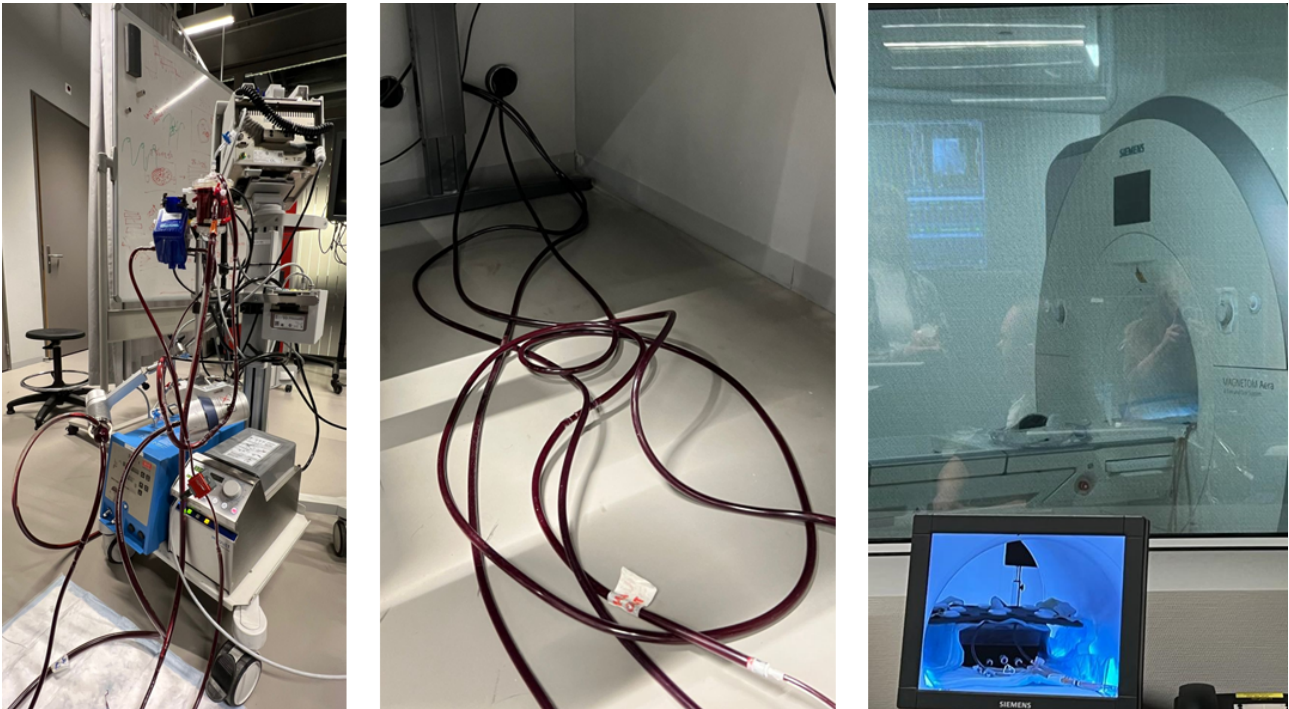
Setup for MRI experiments. The driving system is placed in the control room of the MRI. The 8m long lines of tubing were fed through the holes in the wall. The tubing was connected to the liver reservoir placed in the MRI scanner.
